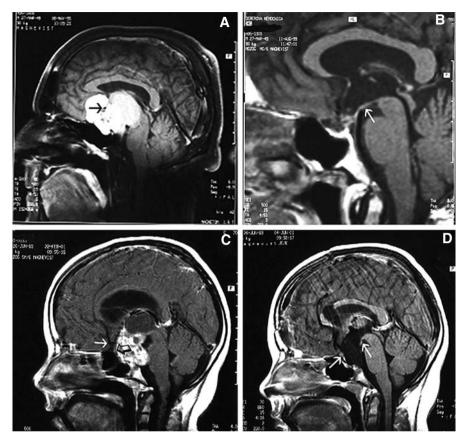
Preoperative and postoperative MRI scans of suprasellar extraventricular (A, B) and intraventricular and extraventricular (C, D) craniopharyngiomas. A, C Arrow: AcomA, open arrow: chiasm. B Preserved floor of the third ventricle (arrow) after subfrontal tumor removal. D Remnants of the ventricular floor after combined transcallosal and trans-lamina terminalis tumor removal (arrows)
